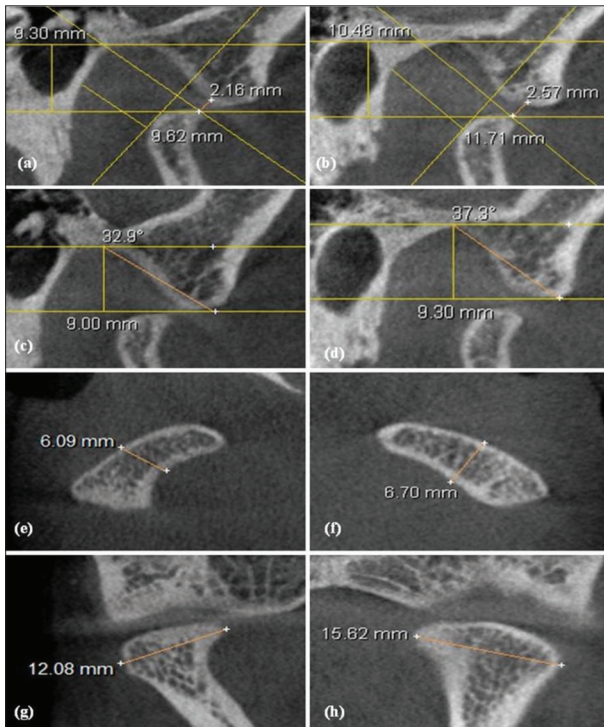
Dimensions of anatomical structures, right and left temporomandibular joint (TMJ) on CBCT; height of joint space of the right (front, posterior and upper joint space) (a), and the left (b) TMJ; sagittal condylar angle and depth of mandibular fossa of the right (c), and the left (d) TMJ; anterior–posterior dimension of a condyle head of the right (e), and the left (f) TMJ; medi–olateral dimension of a condyle head of the right (g), and the left (h) TMJ
